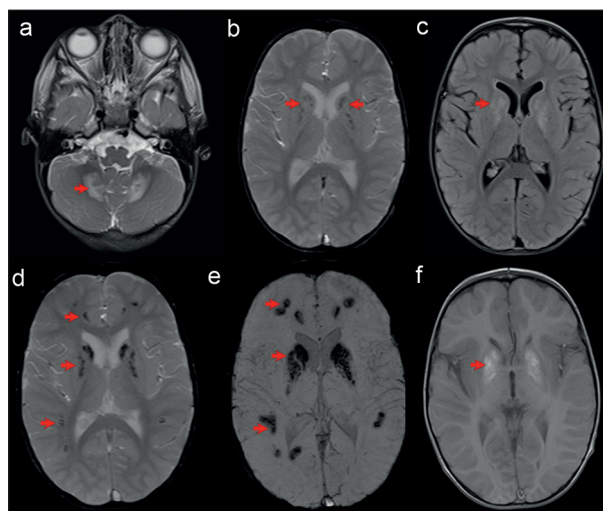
1.5T Brain MRI of the patient: a-c were performed at the age of 2.5 years; a- pathologically increased signal of the brain parenchyma on T2/DVI/FLAIR sequences, in the projection of the white matter of the cerebellum; b- in the projection of nucleus caudate, globus pallidus, putamen and dentate nuclei there are punctiform and slightly linear zones of reduced signal intensity on the chemo-sensitive sequence, which are hyperintense on T1WI (c); d-f Brain MRI were performed at the age of 4 years; d- in the same regions, there are significantly larger hypointense signal lesions on T2WI/FLAIR sequences and SWI sequences (e), hyperintense on T1WI (f), corresponding to punctiform and serpiginous calcification zones. Mild ventriculomegaly is shown on these sequences.
